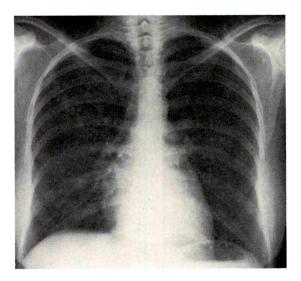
Forty-eight hours after first chest roentgenogram. Nearly complete clearing in seen.
